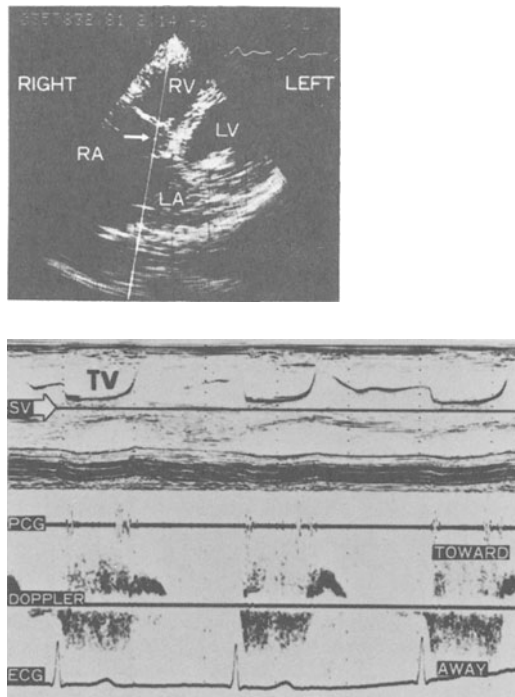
Phased array sector image of a patient with tricuspid regurgitation. The imaging plane is a foreshortened four chamber view. The cursor indicates the B-mode line from which the M-mode echocardiogram is obtained and passes through the tricuspid valve. The position on the B-mode line of the range gate from which the Doppler is sampled is indicated by the arrow. The M-mode echocardiogram is shown below and the position of the sample
